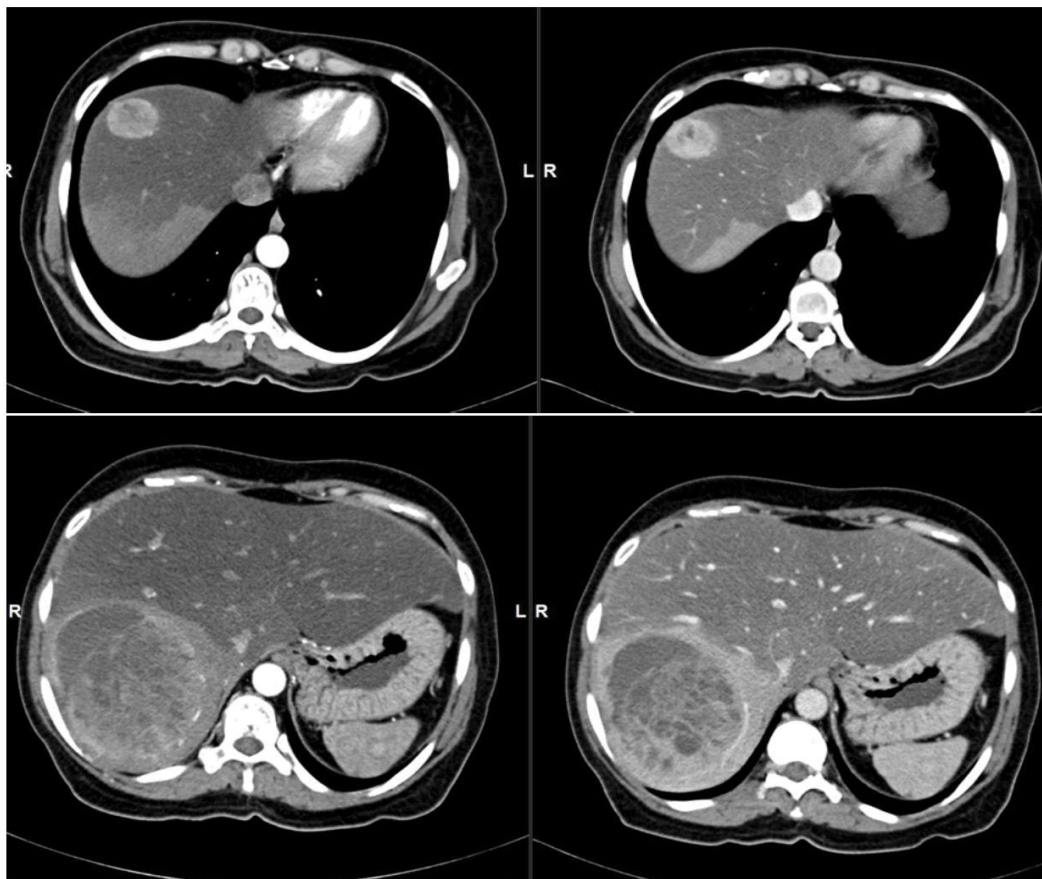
Primary NET. (a,b) Contrast enhanced CT axial sections shows a well-defined small round lesion in segment VII/VIII with intense marginal nodular enhancement in arterial phase (a) and no washout in portal phase (b) in the background of fatty liver and areas of fat sparing; (c,d) Contrast enhanced CT axial sections shows a well defined large lesion in segment VI with intense marginal nodular enhancement in arterial phase (a) and no washout in portal phase (b) in the background of fatty liver and areas of fat sparing.
